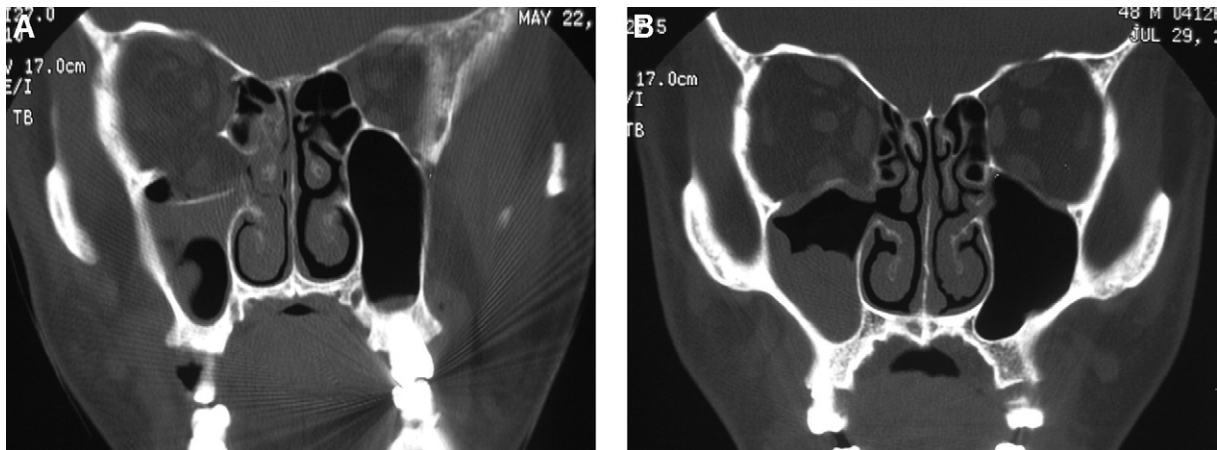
(A) Preoperative CT scan shows an inferior blowout fracture of the right orbit. (B) CT scan taken at two months after surgery shows a well-reduced orbital floor.
